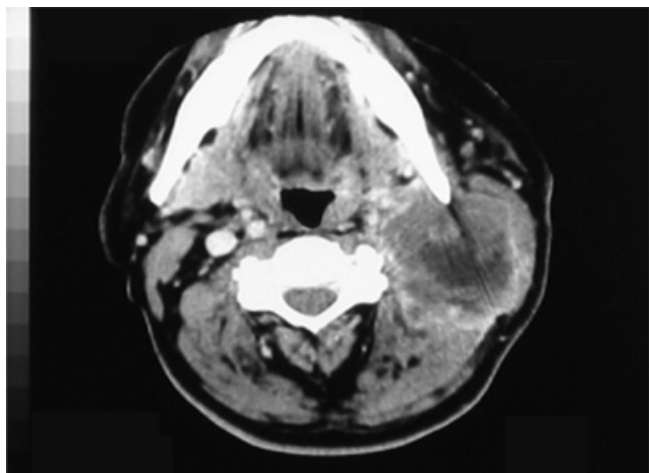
A 77-year-old male with metastatic lymph node of larynx SCC with central necrosis and conglomerated appearance that is adherent to internal carotid artery with type I, V and VI CT manifestations.
